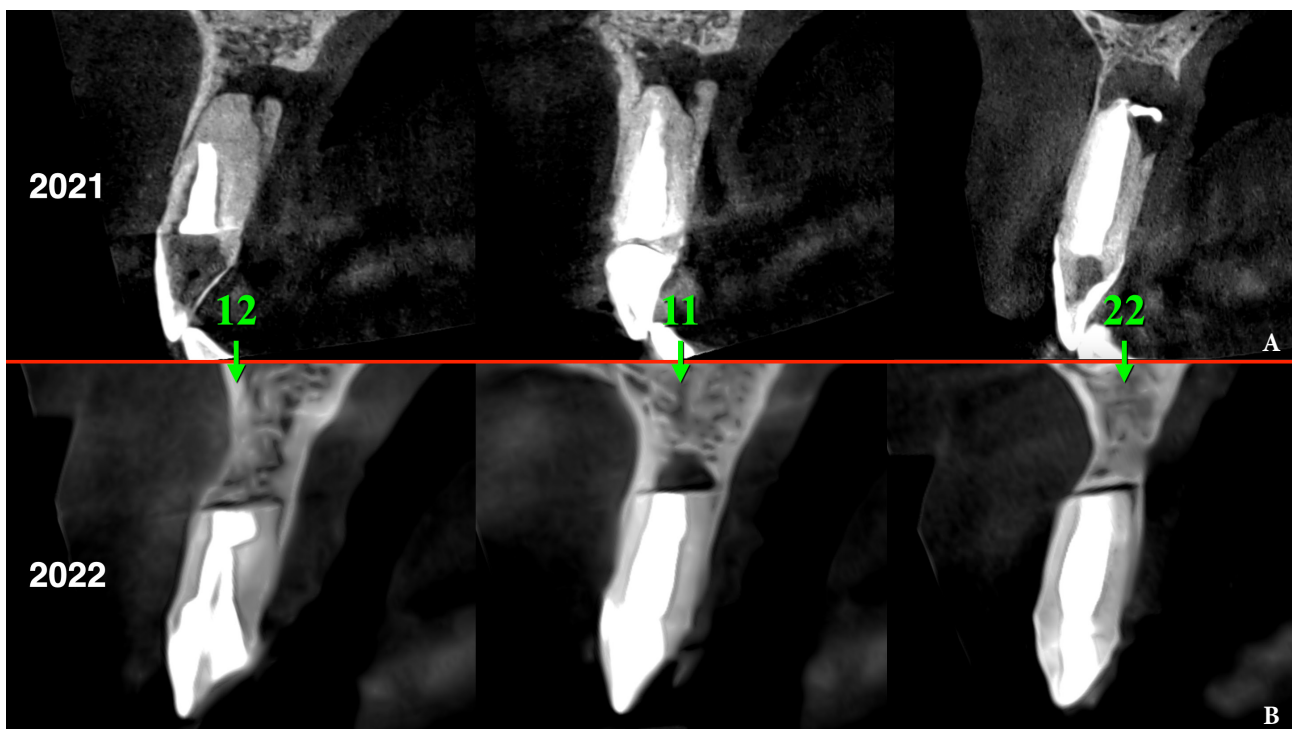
Sagittal CBCT scans before (A: 2021) and 1.5 year after (B: 2022) the endodontic microsurgery. Notes a repair of the vestibular and palatal cortical plates along with partial repair of cancellous bone substance. Repaired bone areas are indicated by arrows. 12, upper right lateral incisor; 11, upper right central incisor; 22, upper left lateral incisor.
